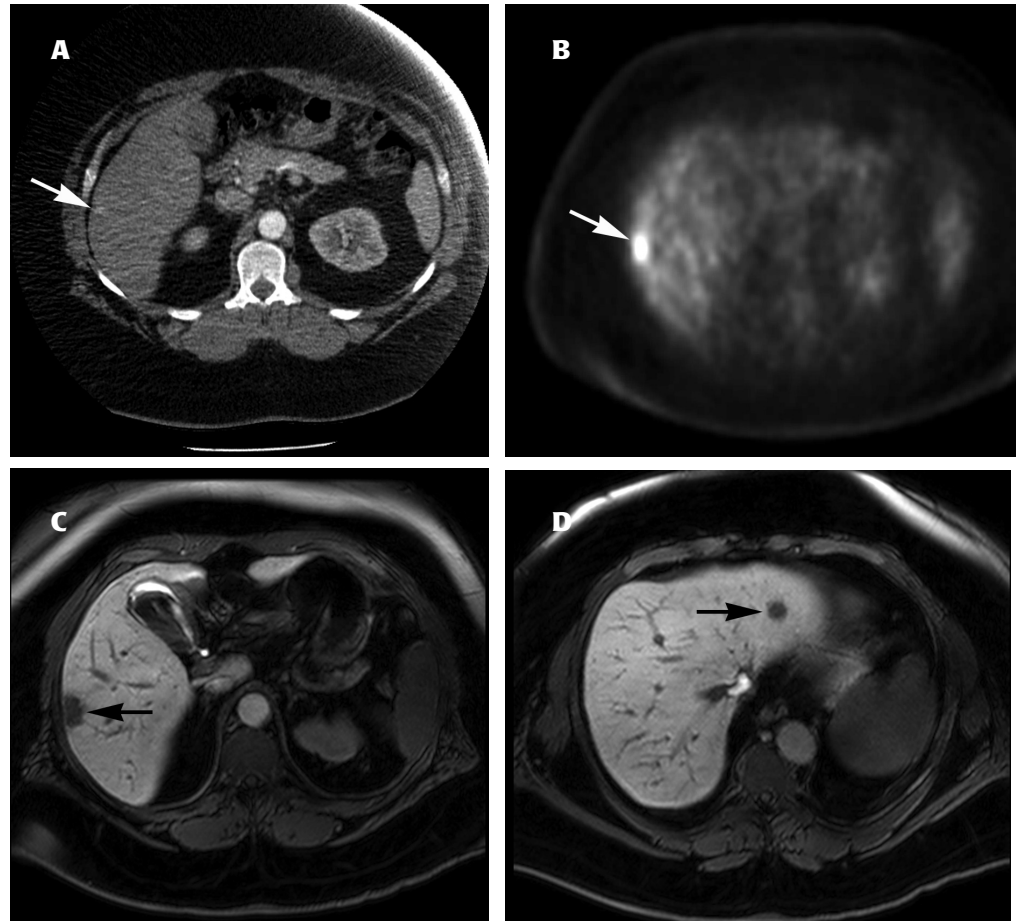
(A) An axial CT image at the level of the lower right lobe of the liver obtained during the late arterial phase after administration of intravenous iodinated contrast material demonstrates a heterogeneous focus (arrow) along the lateral margin. The remainder of the liver was unremarkable on this examination (not shown). (B) A PET image corresponding to the same anatomic level as Figure A demonstrates avid focal uptake within the lateral right hepatic lobe (arrow). (C) A 20-minute delayed hepatobiliary-phase MR image with Gadobutrol. A discrete metastatic lesion is well depicted as a focal area of hypointense signal (arrow) corresponding to the area of faint abnormality on CT. (D) A 20-minute delayed hepatobiliary-phase MR image with Gadobutrol. Another discrete metastatic lesion is depicted as focal areas of hypointense signal in the left hepatic lobe (arrow). Up to 4 additional lesions were seen within the liver consistent with metastatic disease (not shown).
